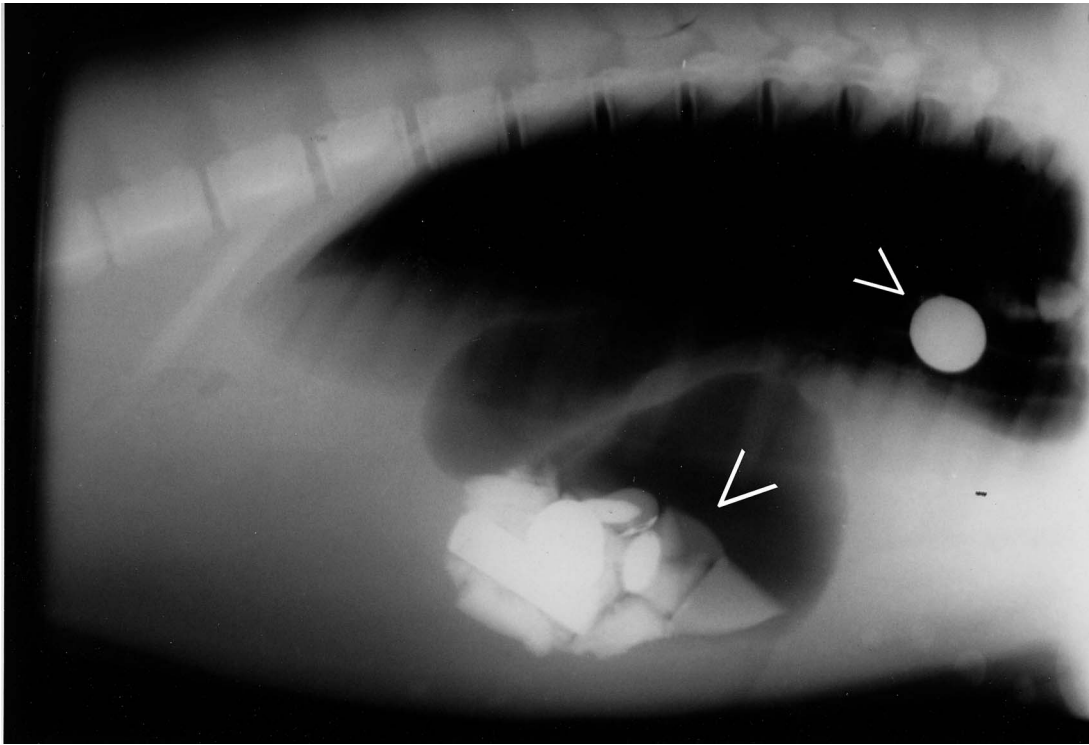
Lateral radiograph of an immature male *Inia geoffrensis* with metallic gastric and esophageal foreign bodies, noted by arrowheads. These foreign bodies were successfully removed manually. Photograph by the author (EOB).
